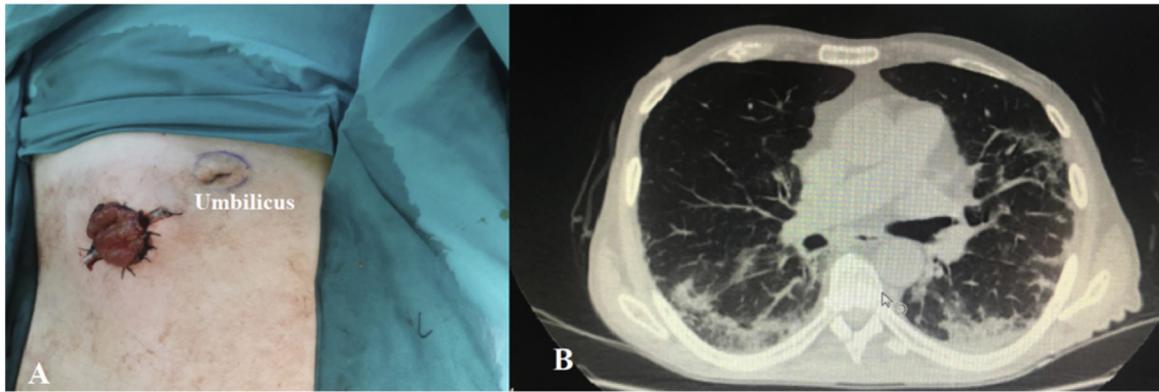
Postoperative appearance of ileostomy on the abdominal anterior wall of the case (A) pulmonary computed tomography image compatible with COVID-19 of the case (B).
